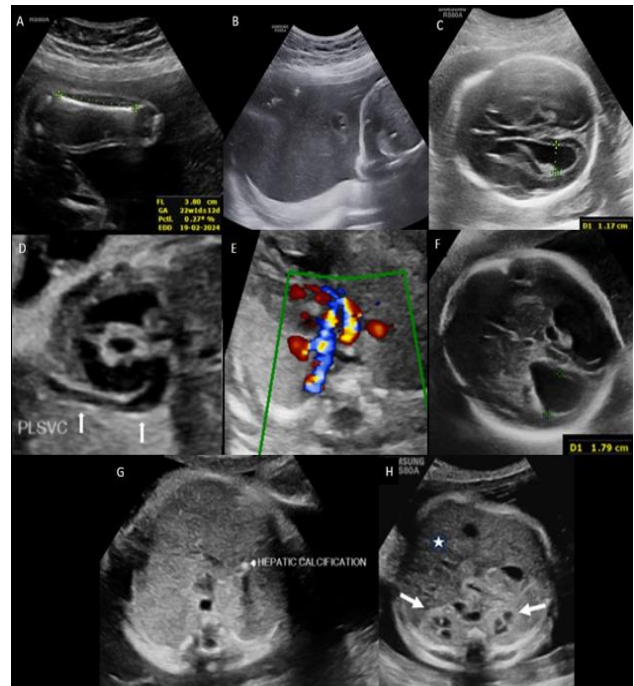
B-mode ultrasound of the fetus shows short femur length less than 1st centile (A) with polyhydramnios (B) and mild ventriculomegaly (C) at 25 weeks of gestation. B-mode and colour Doppler image showing persistent left SVC draining in the coronary sinus (D) and in the three-vessel view (E). B-mode axial trans-ventricular section of fetal brain at 32 weeks shows severe ventriculomegaly measuring 17.9 mm (F). Axial section of the fetal abdomen shows a single focus of hepatic calcification (G) and (H) shows bilateral echogenic kidneys (solid arrows). The liver in image (H) appears hypochoic (star).
